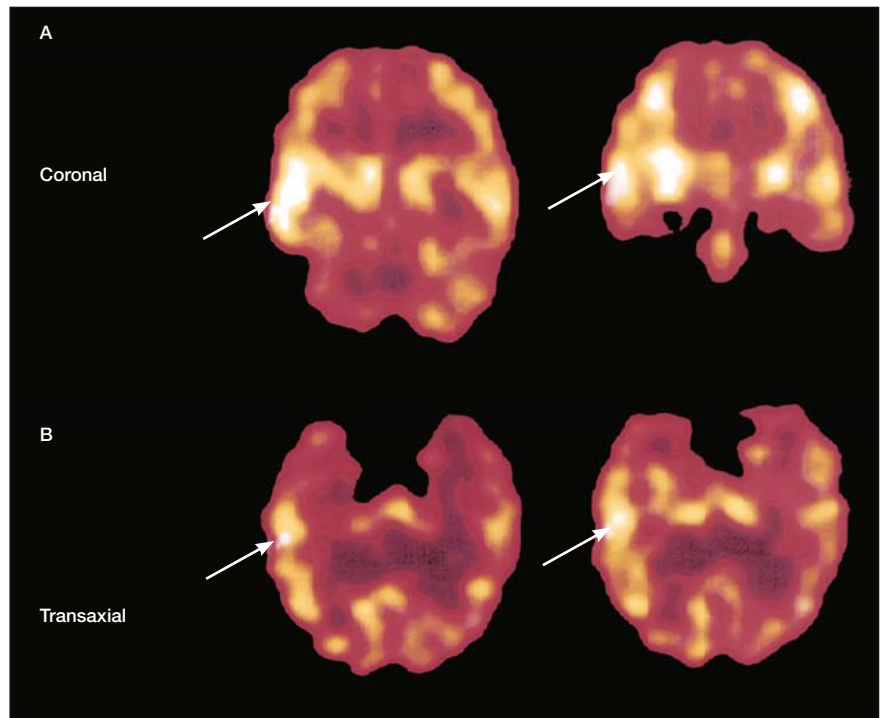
Coronal (A) and axial (B) ^{99m}Tc HMPAO SPECT images show increased perfusion in the right anterior temporal lobe (arrows). Courtesy of Dr. Rod C. Scott, Institute of Child Health, London, UK.
